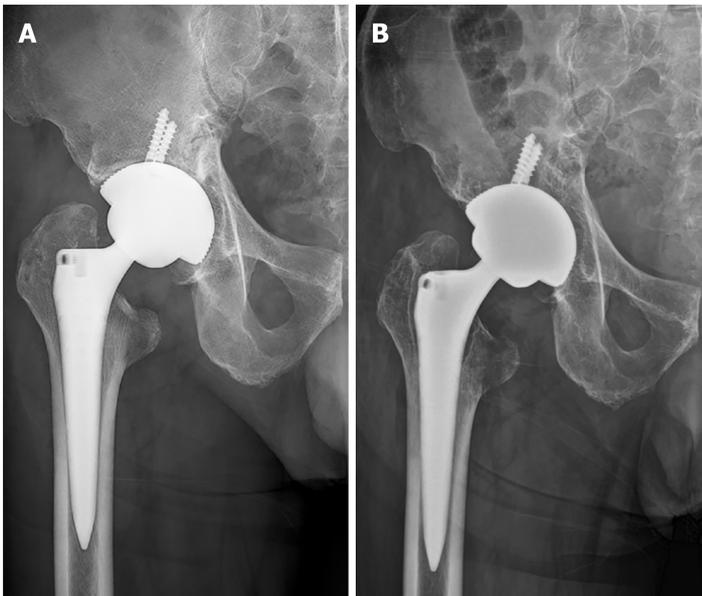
Anterolateral pelvis radiographs of the case. A: Immediately following the index total hip arthroplasty; B: At the time of initial visit to our institution.
